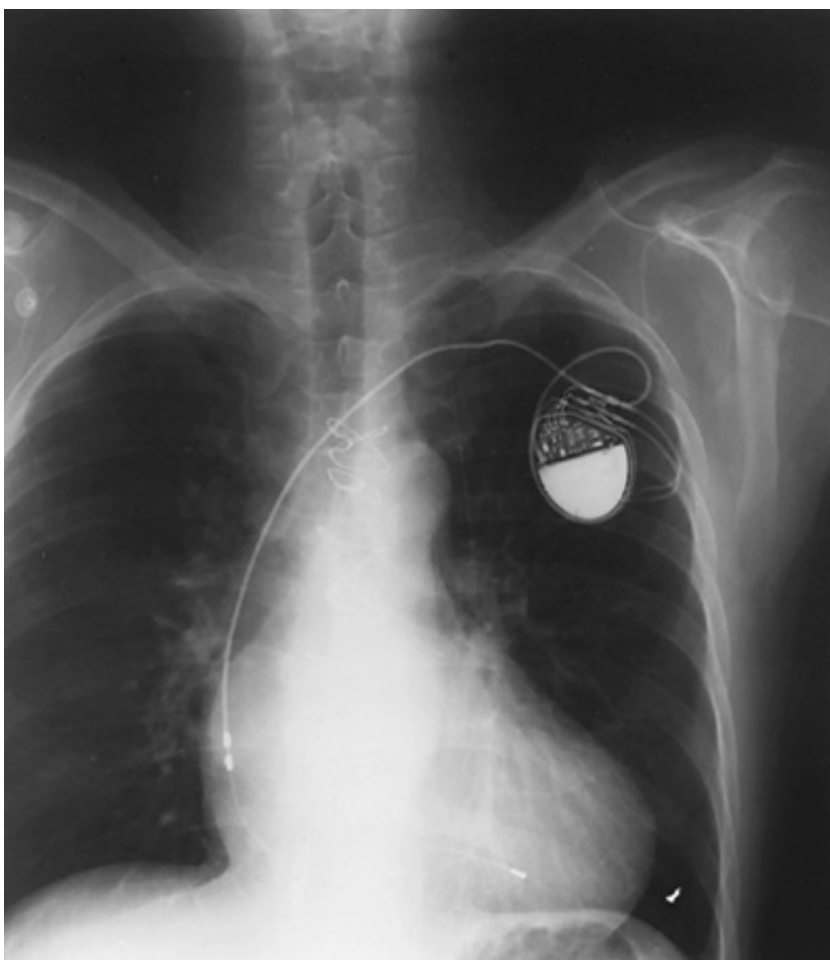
Chest x-ray showing a single lead in the heart. Note the bipolar electrodes in the atrium and the single electrode in the ventricle. This pacemaker system is capable of VDD pacing. Therefore, it senses atrial depolarizations and can pace or sense in the ventricle.
